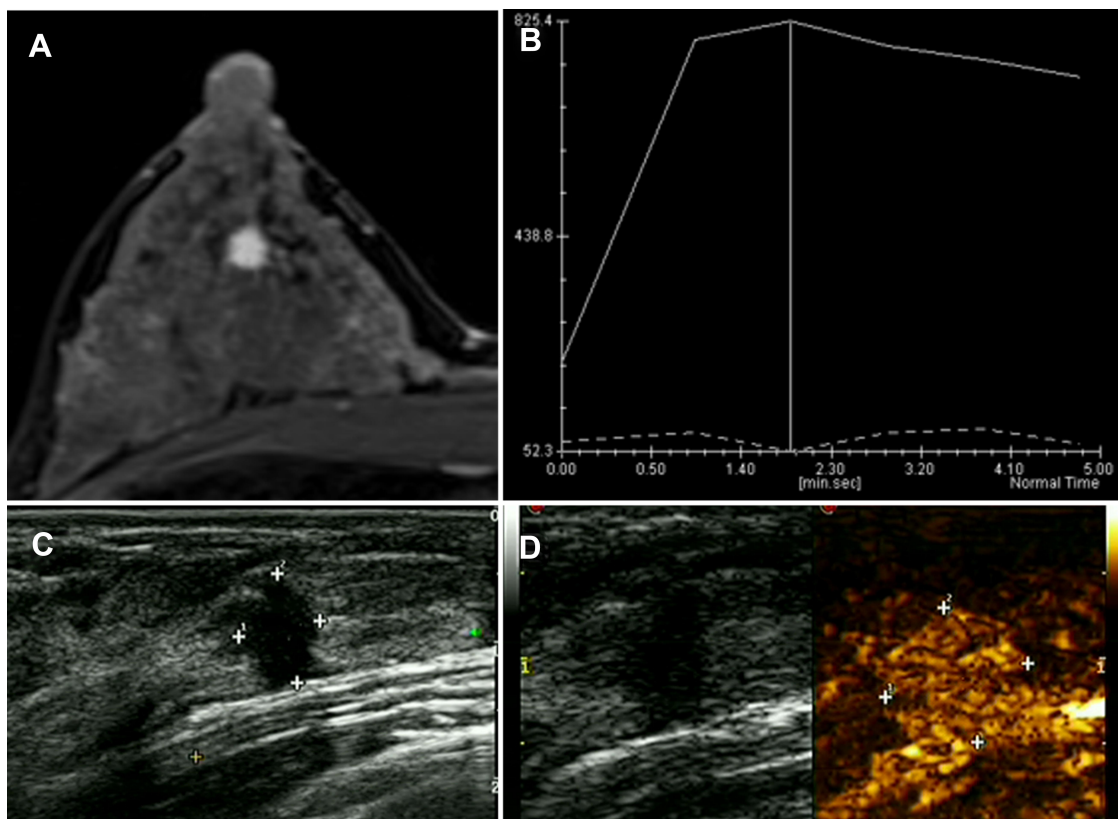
A 35-year-old female patient found a breast lump in the right outer lower quadrant when she made a breast screening. The examination was normal. (A) DCE-MRI reported mass-like hyperenhancement. (B) The TIC curve showed wash-out type. (C) The US presented irregular hypoechoic lesion sized 6*8 mm, and the surrounding tissues were tangled. (D) CEUS showed homogeneous enhancement and hyperenhancement. After the enhancement, the border slightly expanded. The pathology result is invasive ductal carcinoma (IDC).
